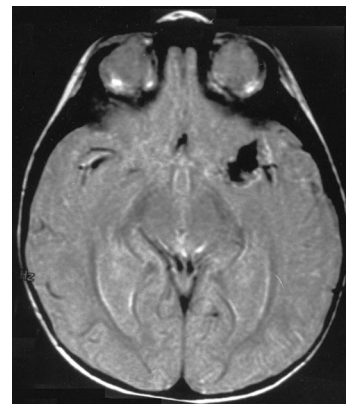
Patient 2. This axial, fluid-attenuated inversion recovery, magnetic resonance imaging scan obtained at the time of the initial presentation of the 10-month-old patient revealed a complex flow void pattern for the giant left MCA aneurysm.
